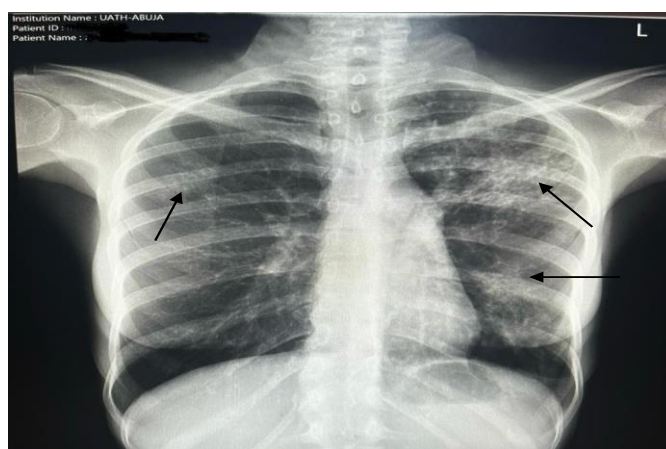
plain Chest radiograph showing patchy reticulonodular opacities (black arrows) consistent with consolidation.
